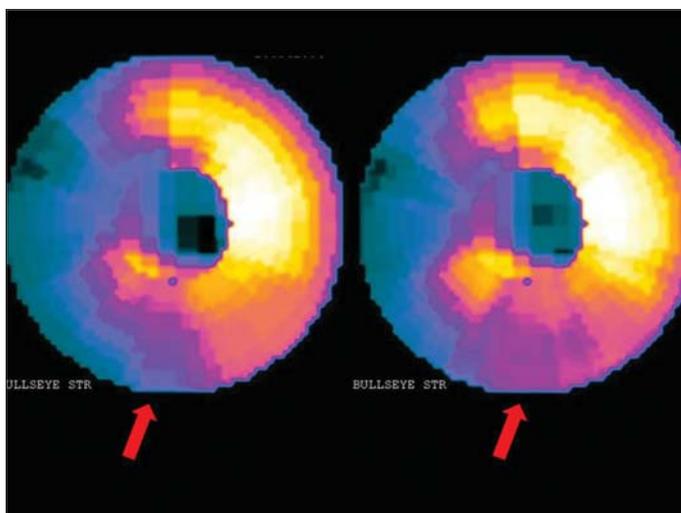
Quantitative thallium-201 scintigraphy (Bull's Eye technique) of initial and after procedure infarct size
